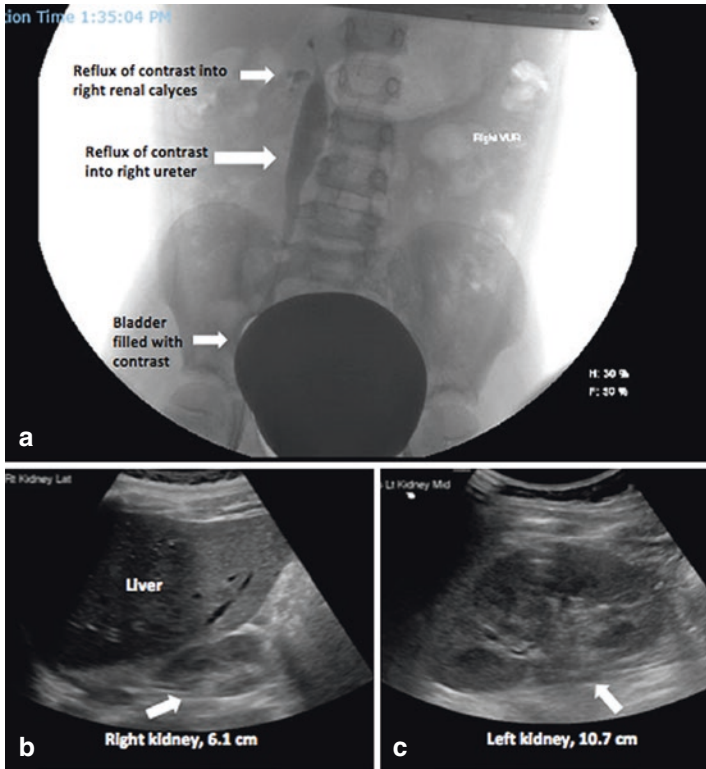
(a) Voiding cystourethrogram from 9 year old patient with right vesicoureteral reflux (b) Renal ultrasonography showing small echogenic right kidney adjacent to liver (c) Hypertrophied left kidney in same patient; mean renal length in normal 9 year old child 9.0 cm (Images courtesy of University of Iowa Hospitals and Clinics)
